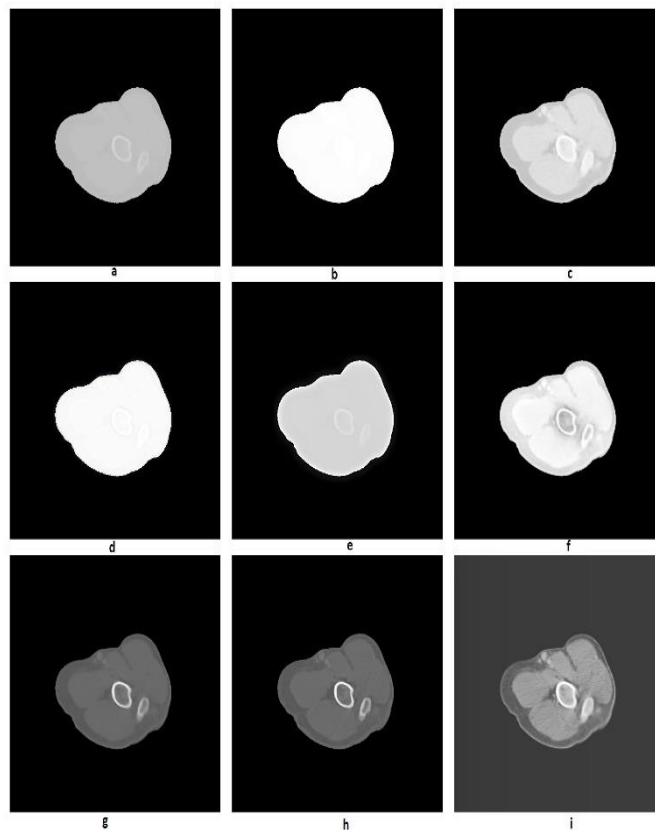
Enhanced test CT image of Arm by a) Reinhard (b) Kim (c) Khan (d) Li (e) Liang (f) Shibata (g) Al-Ameen (h) Gandhamal (i) Proposed, in the reading order.
